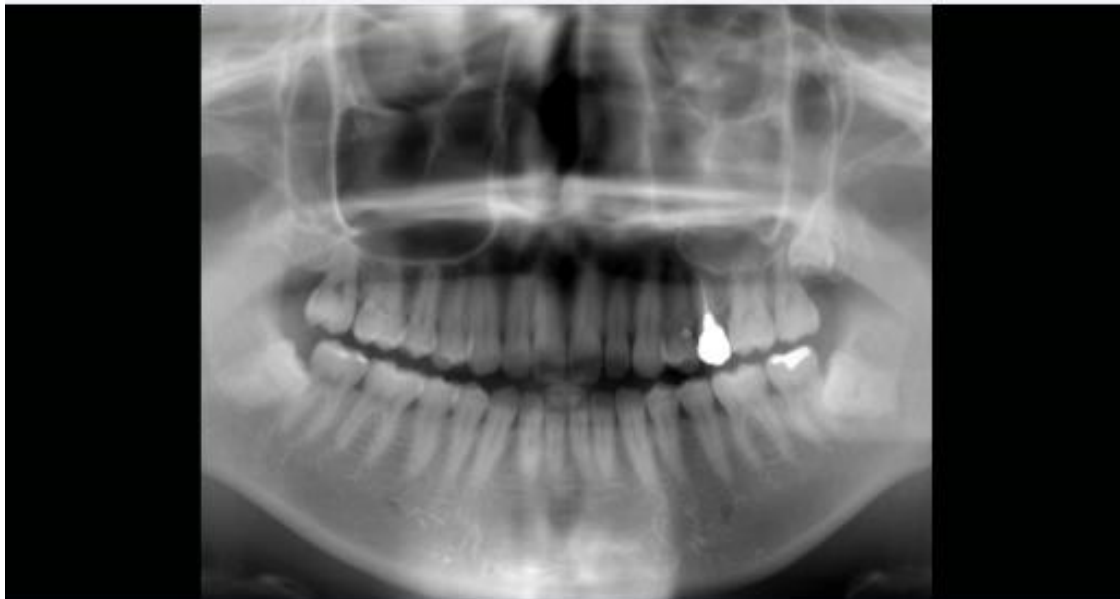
Region of interest on panoramic radiograph (image credit [41]).
